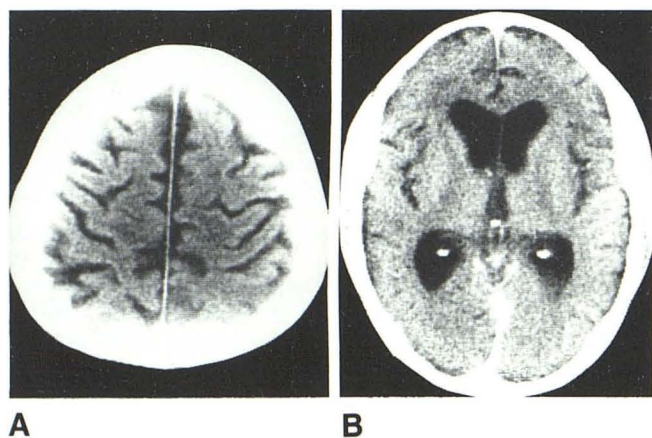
CT scans of cortical atrophy without contrast enhancement. A, Moderate cortical atrophy. B, Moderately dilated lateral ventricles.
